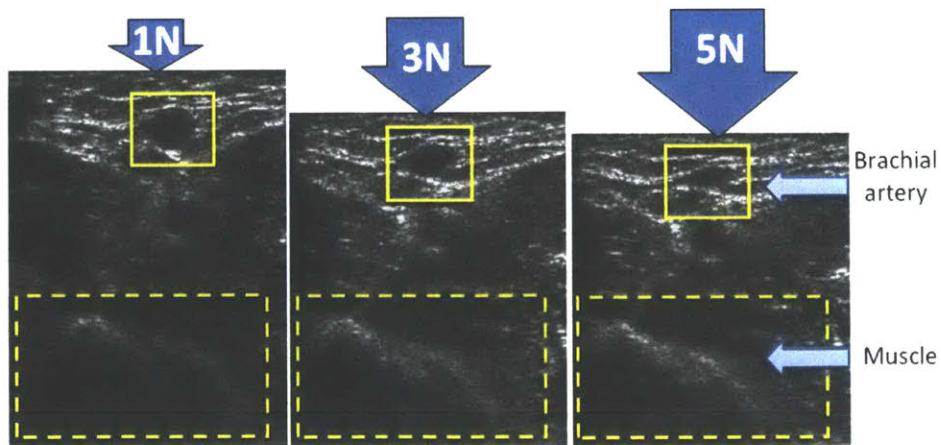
Ultrasound image variability
